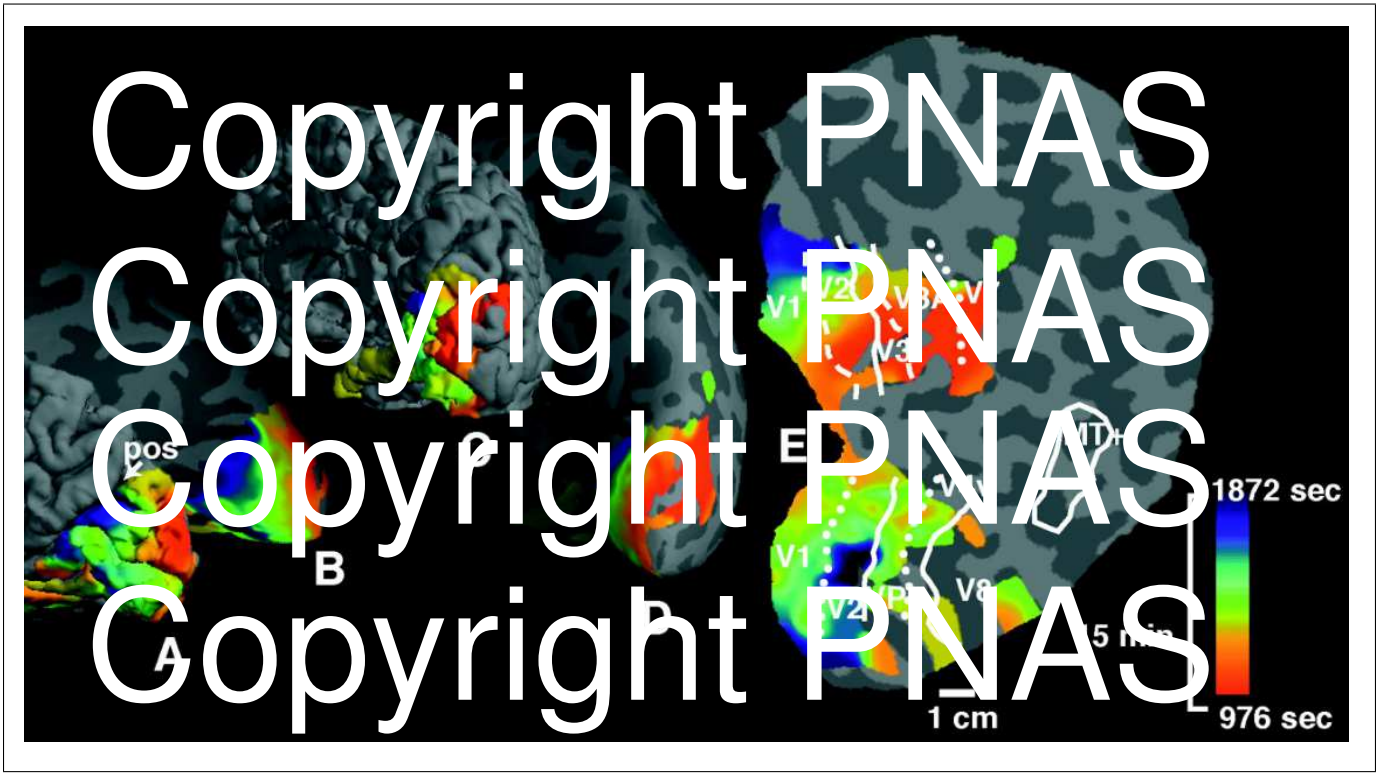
Source localization of the magnetic resonance (MR) data signal of SD (from⁵). Color code: time from onset, locations showing the first MR signals of SD are coded in red, later times are coded by green and blue (see color scale to the right). Signals from the first 975 seconds were not recorded because the migraine attack was triggered outside the MR imaging facility. (A) The data on folded right posterior pole hemispheric cortex; (B) the same data on inflated cortical surface; (C and D) the same data shown on the entire hemisphere from posterior-medial view (oblique forward facing), folded and inflated, respectively. As described in the original study⁵, MR data were not acquired from the extreme posterior tip of the occipital pole (rear-most portion). (E) A fully flattened view of the cortical surface. The aura-related changes are localized wave segments. Note that in the flattened cortex was cut along the steep sulcus calcarine to avoid large area distortions induced by the flattening process. The colored border to the left is the cut edge that should be considered being connected such that the color match up as seen in (B and D). (Copyright permission from authors granted, from PNAS is requested.)
